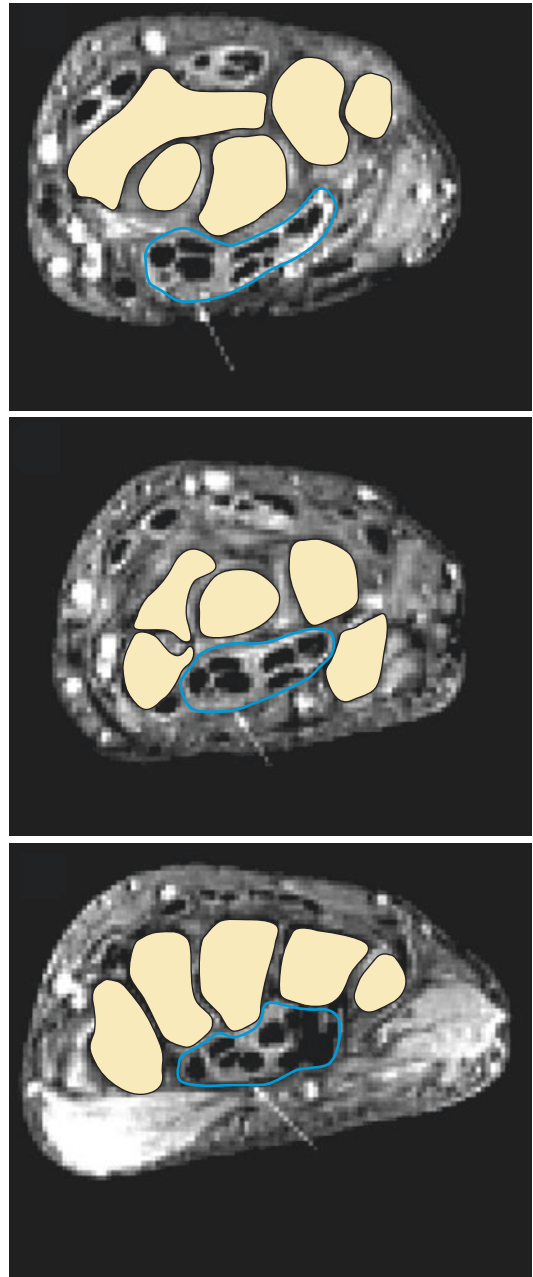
Axial MRI images at three levels in the carpal tunnel which enable cross-sectional area measurements to be made
